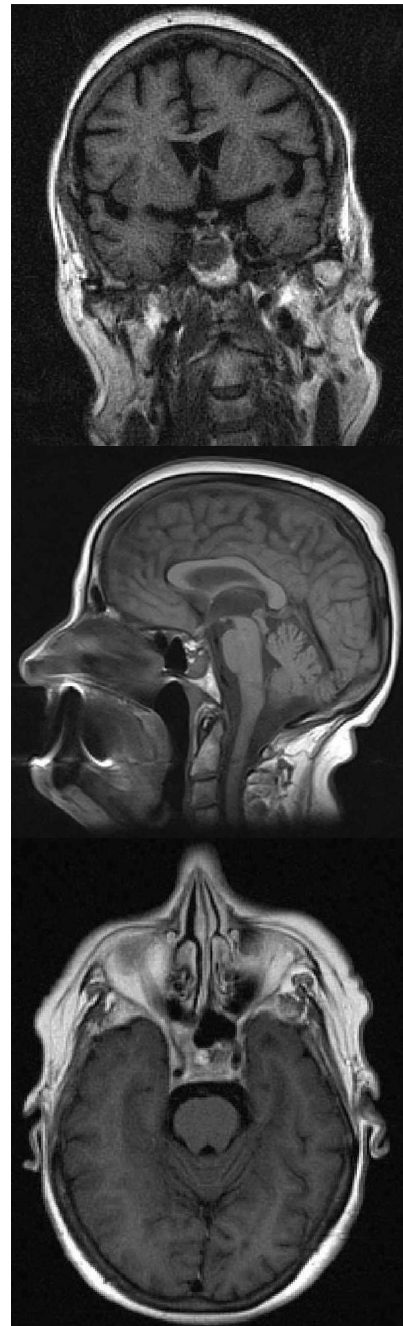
Postoperative MRI images. Complete removal of sellar colloid cyst
